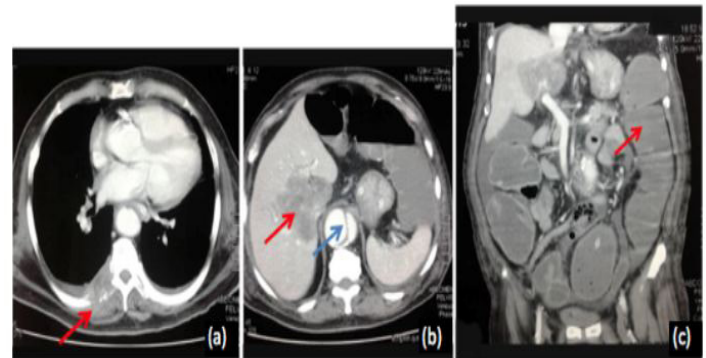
(a-c): CT scan abdomen and pelvis with contrast of an 80-yrs-old male with metastasized Colorectal Cancer. (a) Axial section lower thorax shows mild bilateral pleural effusion and erosion of the proximal end of the 8th rib on right side (arrow) with associated soft tissue density mass. These changes are suggestive of skeletal metastasis. (b) Axial section of upper abdomen shows a large hypodense mass (red arrow) in the liver with a few smaller focal lesions suggestive of hepatic metastasis. Partially thrombosed dissecting aneurysm of abdominal aorta (blue arrow) is also noted. (c) Coronal section of abdomen and pelvis shows moderately severe dilation of large intestine (arrow) and focal mass in the liver.
